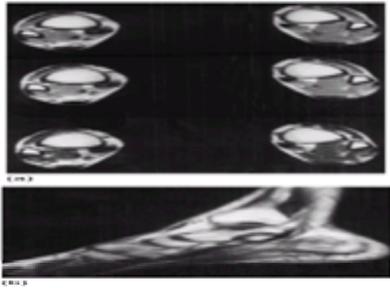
Ruptured tibialis posterior tendon; sagittal and axial MR images. (a) The axial slices show both ankles. On the normal left side, the tendons behind the medial malleolus are well defined and compact. On the right, there is obvious thickening. This is due to retraction and the changes are easily identified then on the sagittal image (b).
